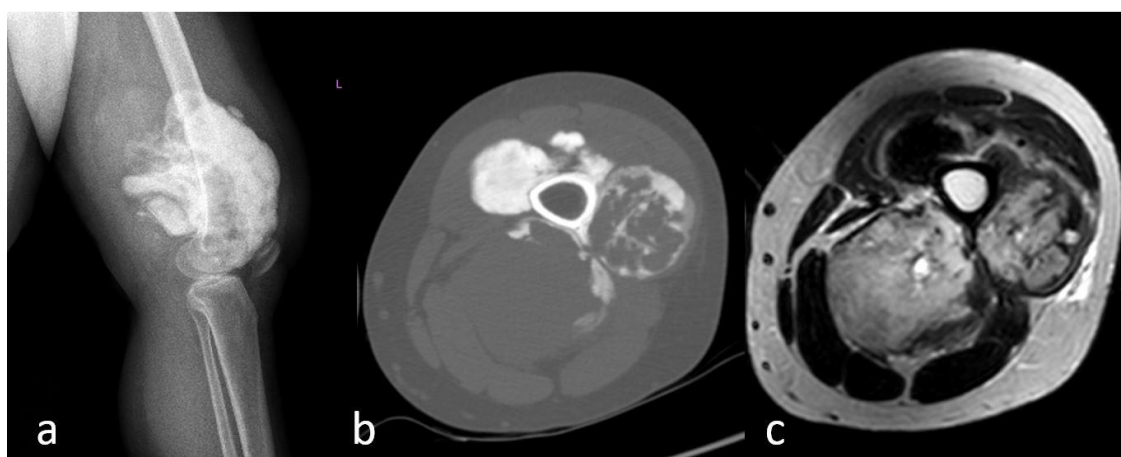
The x-ray and CT images of the mass showing calcification and new bone construction and not showing infiltration of the medulla in the distal metaphyseal region of the femur (a-c).
